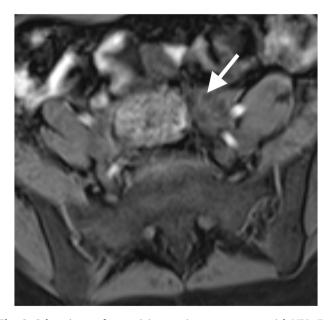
Subcentimeter fat-containing ovarian teratoma on axial MRI: Fat-suppressed T1 weighted image shows lesion is now hypointense (arrow), confirming the presence of macroscopic fat.
